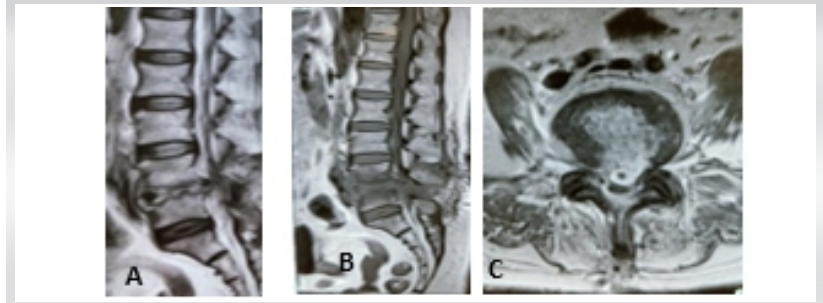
Magnetic resonance imaging showing destruction of L4-5 intervertebral disc. (A) Sagittal MRI T2 Image, (B) Sagittal MRI T1 Image and (C) Axial MRI Image
